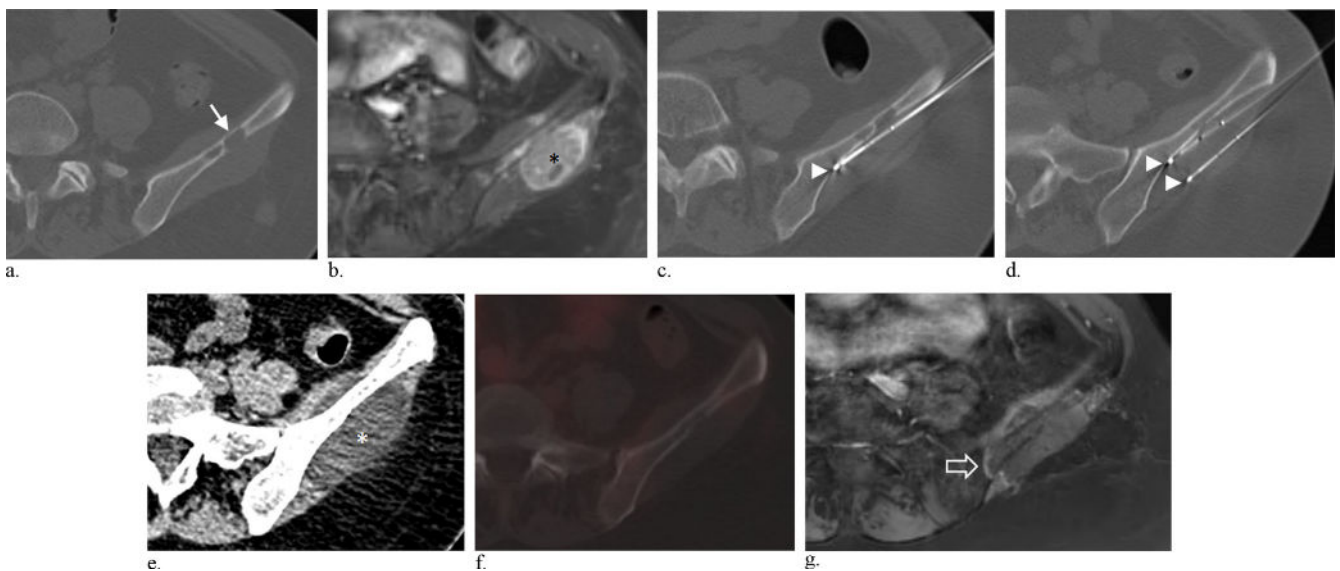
A 52-year-old woman with metastatic leiomyosarcoma and severe left buttock and leg pain that was minimally relieved with oral opioid pain medications. Axial CT with bone windowing (a) and T1-weighted MR imaging after contrast administration with fat suppression (b) show a lytic lesion in the left iliac wing (arrow) with an enhancing soft tissue component (black asterisk). Axial CT images with bone windowing (c, d) show multiple cryoprobes positioned along the posterior wall of the iliac crest (arrowheads). Axial CT image with soft tissue windowing (e) shows the resulting ice ball enveloping the tumor (white asterisk). The patient experienced near-complete pain relief after the procedure. Axial 18-fluorodeoxyglucose PET/CT (f) performed 16 weeks after cryoablation shows no uptake in the treated metastasis. Axial T1-weighted MR imaging after contrast administration with fat suppression (g) performed 30 weeks after treatment shows a thin rim of enhancing granulation tissue at the margin of the ablation zone (block arrow) and no residual enhancing tumor.
